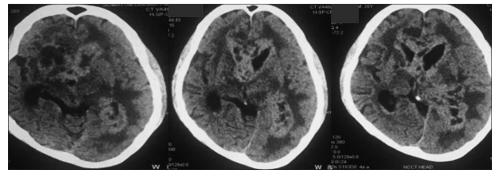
Noncontrast computed tomography scan of brain showing significant diffuse nodular densities around the lateral and third ventricle with irregular ventricular enlargement
